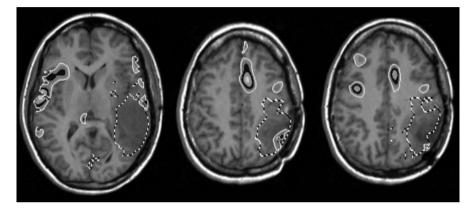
T1-weighted MRI fused with ¹⁵O-PET activation studies (z-scores) [7]. Speech repetition task (left), verb generation (centre), finger tapping (right-hand side). In addition, the area of increased Methionine uptake is shown (dotted-line iso-contour created from the tumor-normalized Meth-PET). We observed that this area is often significantly larger than any visible changes in the MRI study. Both activations for language and motor skills show signals in the area of increased Meth uptake and are consistent with a mild aphasia.
